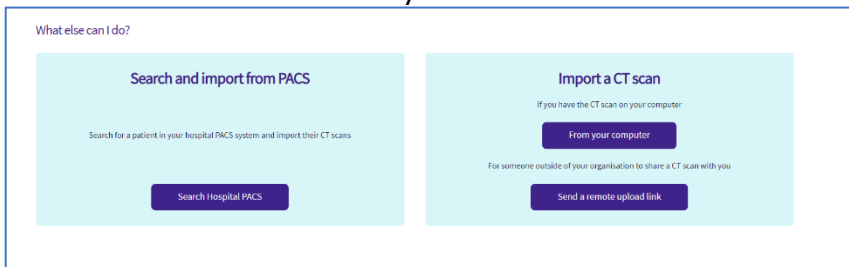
CT scan import option buttons in a Hospital Vault
